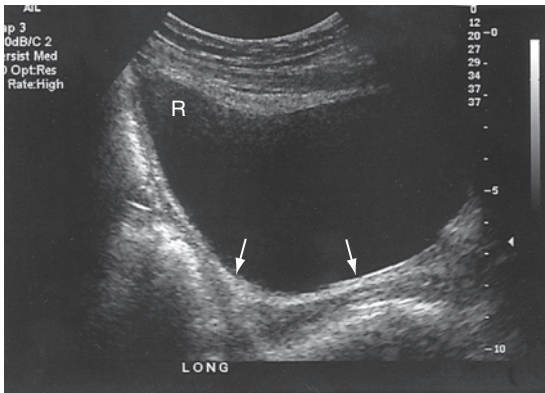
Normal urinary bladder. A sagittal sonogram of the normal distended bladder demonstrates thin walls (arrows) with low-level echoes on its anterior wall which represent reverberation artifact (R).
